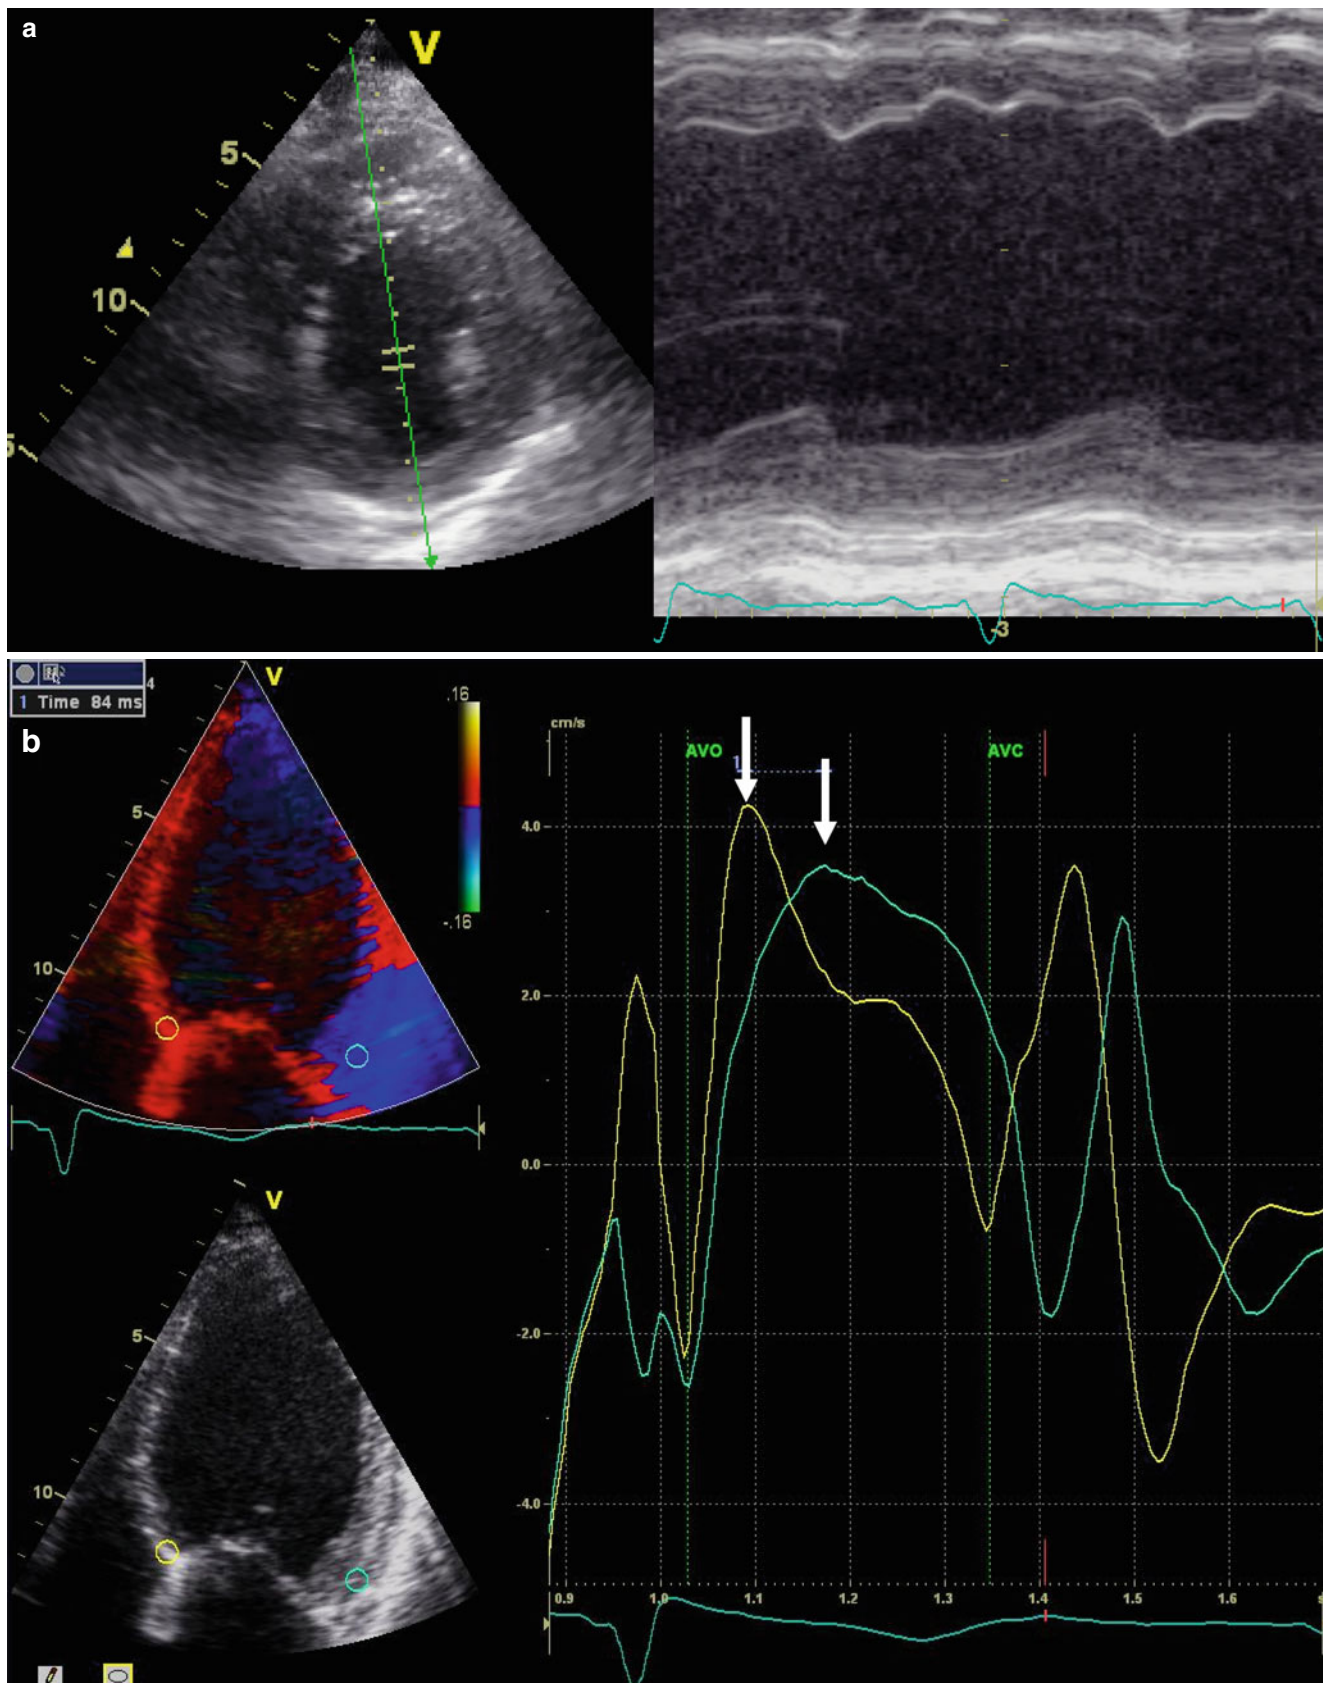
LV dyssynchrony assessment with echocardiography. Several echocardiographic methods have been developed to quantify LV dyssynchrony (see text): septal-to-posterior wall motion delay on M-mode images (a), time delay between peak systolic velocities on TDI images (b), time delay between peak radial strain of the anteroseptal
